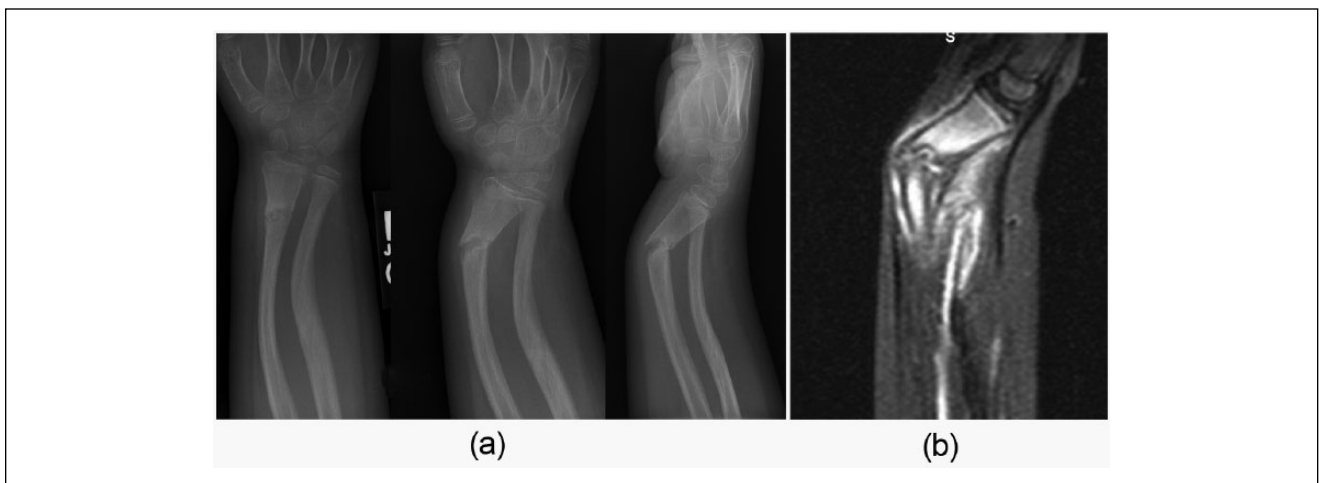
Images after the patient sustained a subsequent injury to his distal radius. (a) Radiographs show a repeat fracture while the (b) magnetic resonance imaging shows a pseudoarthrosis of the distal radius.
